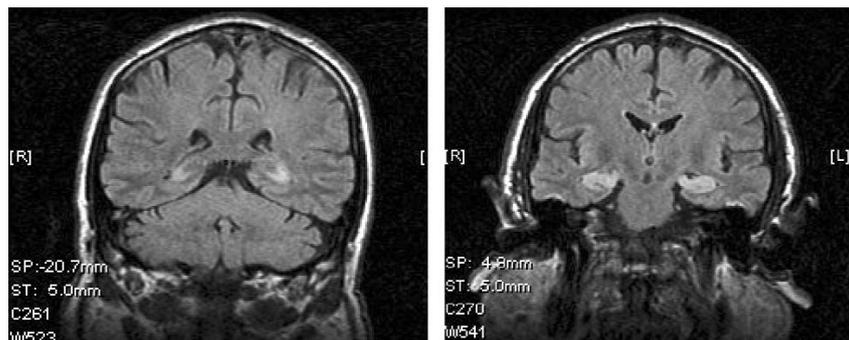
Coronal T2 weighted FLAIR magnetic resonance image of the brain showing the classical appearance of bilateral hippocampal high signal in a patient with VGKC-associated LE.
